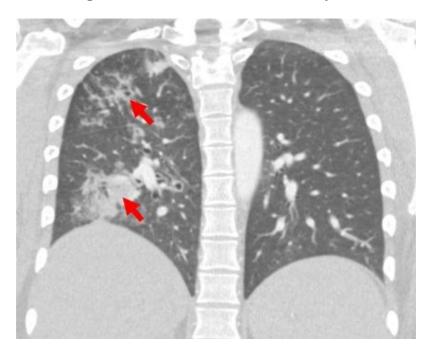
Thoracic CT with contrast demonstrating right upper and lower lobe tree-inbud and ground glass opacities (arrows) consistent with progressing pulmonary coccidioidomycosis.
